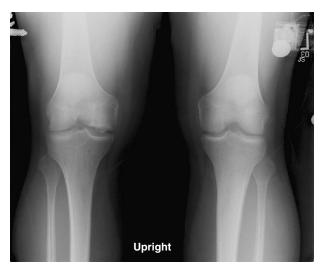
Preoperative anteroposterior radiograph demonstrating osteochondral lesion of the medial femoral condyle.
